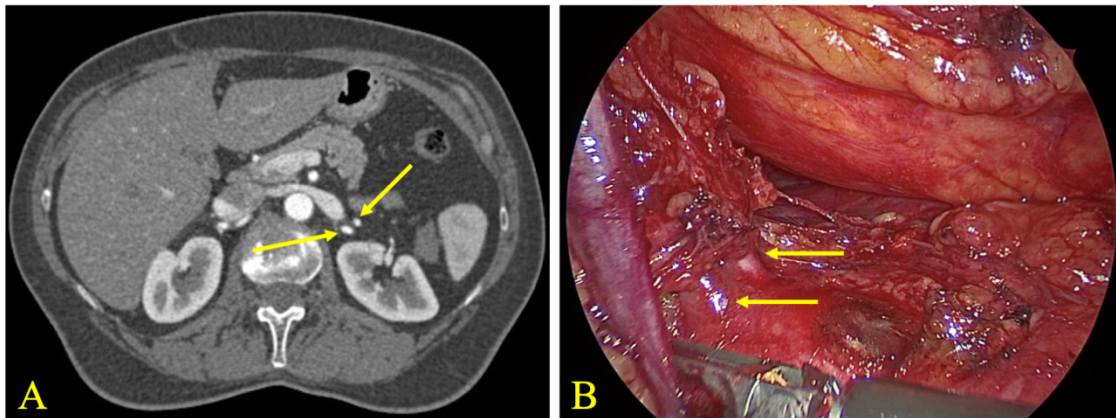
A. CT scan showing a double artery in the left kidney. B. Laparoscopic dissection of the left renal arteries in preparation for the living donor nephrectomy.
